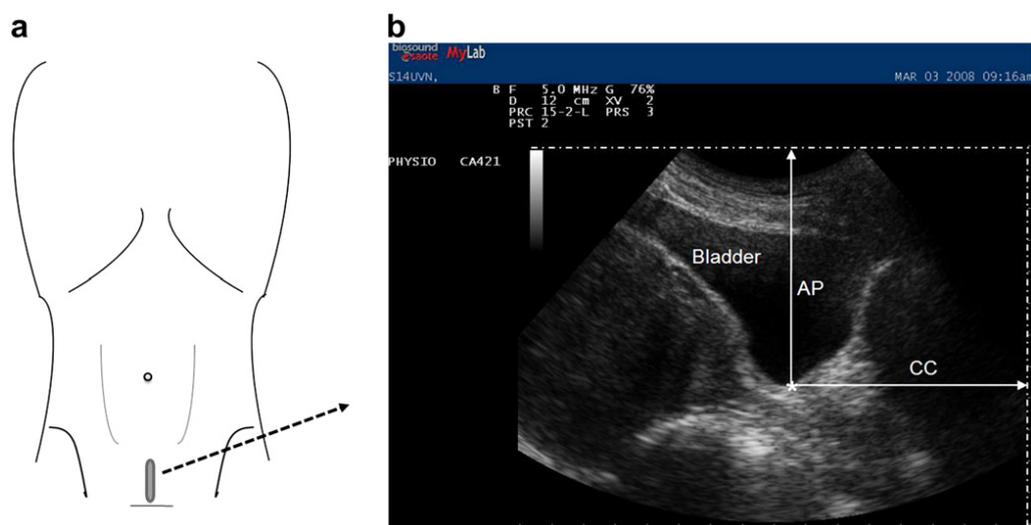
(a) Midline suprapubic (BB) transducer imaging site. (b) Sagittal ultrasound image of the bladder showing the perpendicular anterior/posterior (AP) distance and the cranial/caudal (CC) distance from the top of the USI image and the side of the USI image, respectively, to a reference point (*; the most inferior border of the bladder) on the bladder base.
